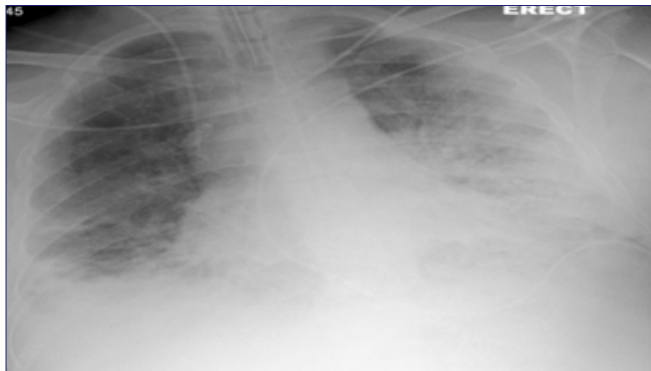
Imaging of lungs following deterioration in respiratory symptoms. a) CXR showing increasing shadowing at both lung bases. b) CT scan showing severe interstitial lung disease.
